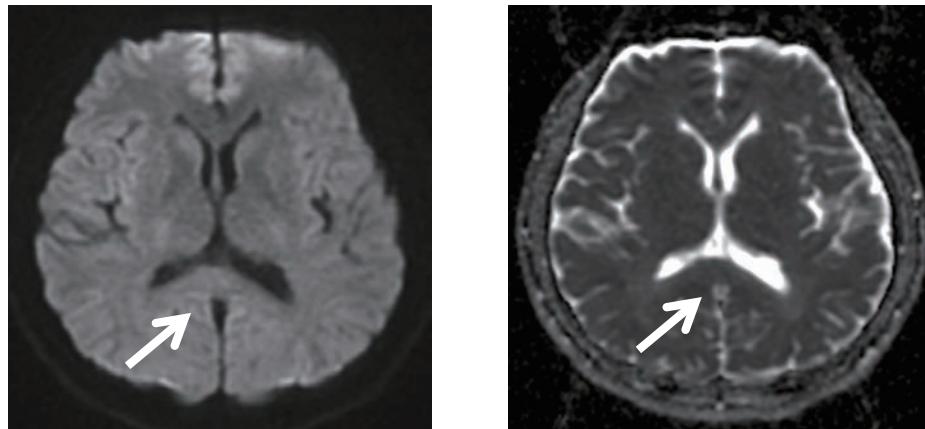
Follow-up head MRI images of the patient. Left image: Axial view of DWI. Right image: ADC image at the same level.
